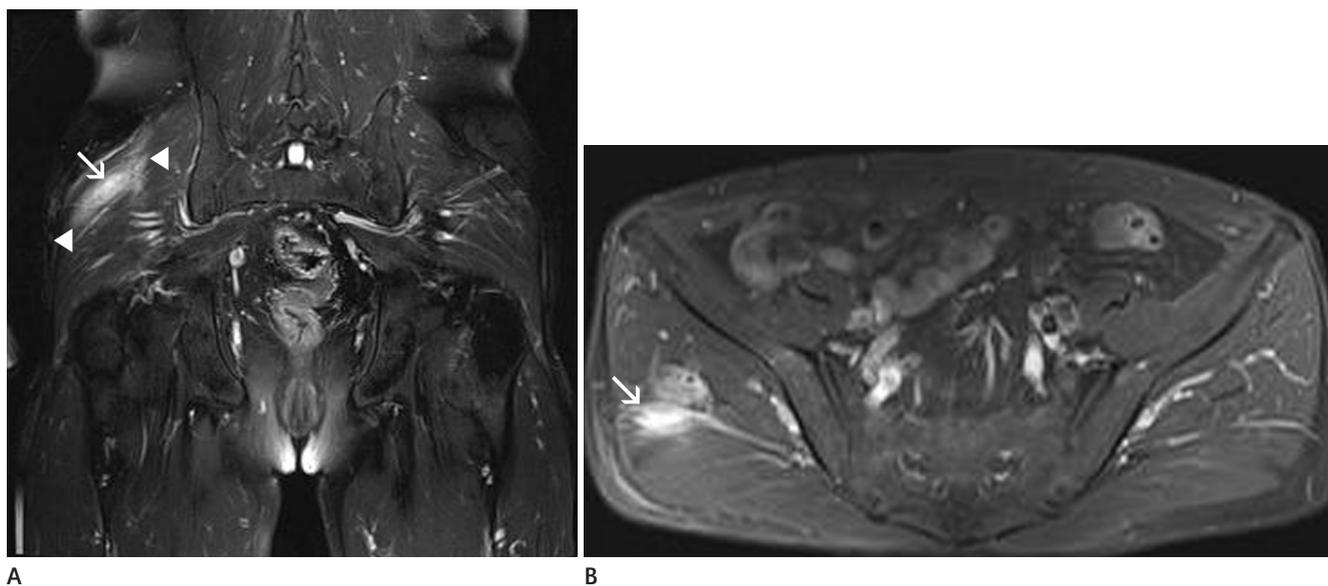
A 50-year-old male patient diagnosed with oropharyngeal cancer two years previously and presently complaining of buttock pain. A. On coronal fat-suppressed T2-weighted image of the pelvis, a hyperintense soft tissue lesion with ill-defined margin (arrow) is seen in the muscular layer of the right buttock. Peritumoral edema (arrowheads) is also noted. B. The lesion shows homogeneous enhancement without degenerative change within the lesion (arrow) on axial fat-suppressed, contrast-enhanced T1-weighted image.
